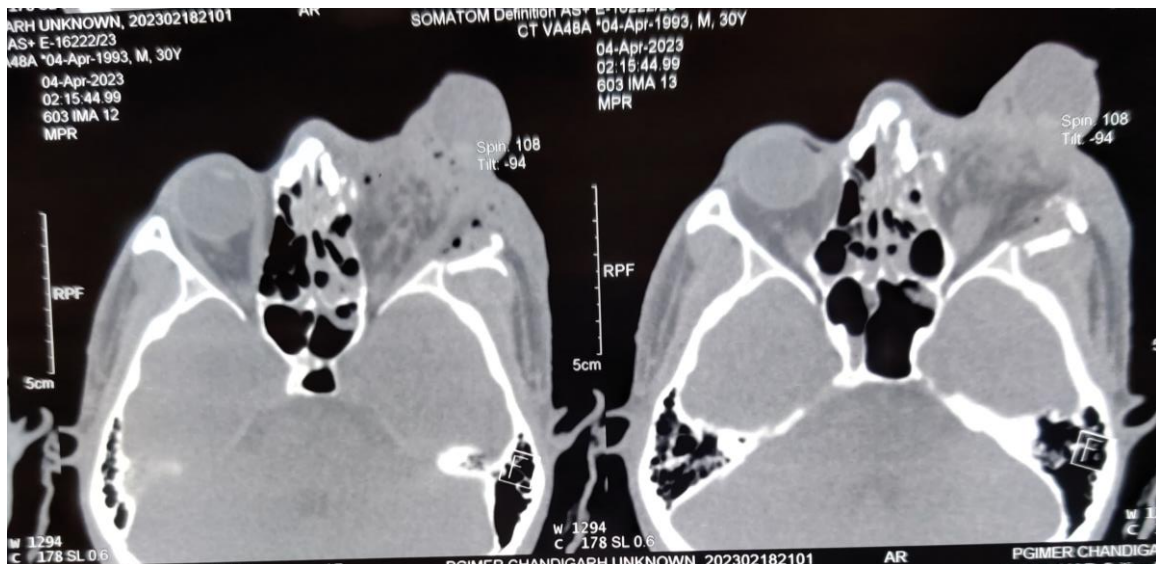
CT scan shows Hemosinus, lateral wall fracture and medial wall fracture.
